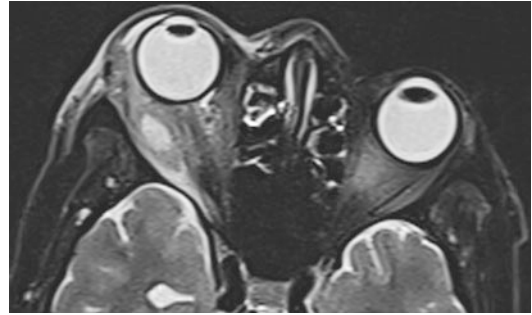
T2-weighted MR image showing cysticercosis of the right lacrimal gland
